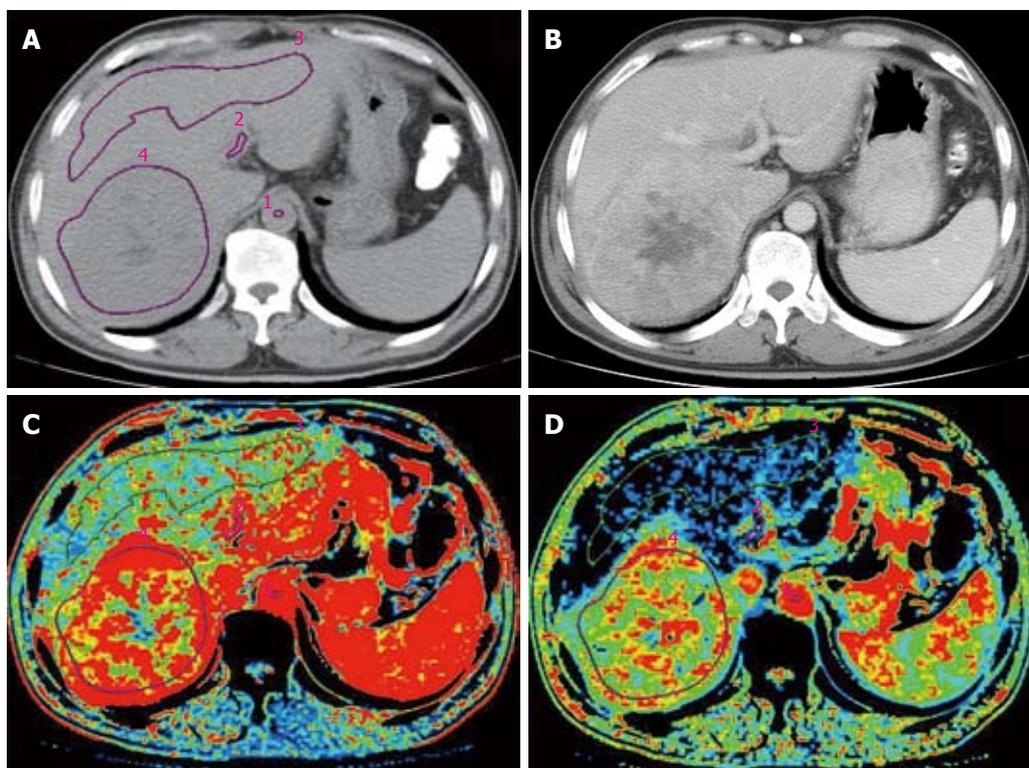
Liver perfusion image of primary hepatic carcinoma at right posterior lobe. A: CT plain image with ROI; B: CT enhanced image of portal vein phase; C: Pseudo-color image of HBF; D: Pseudo-color image of HPI.
